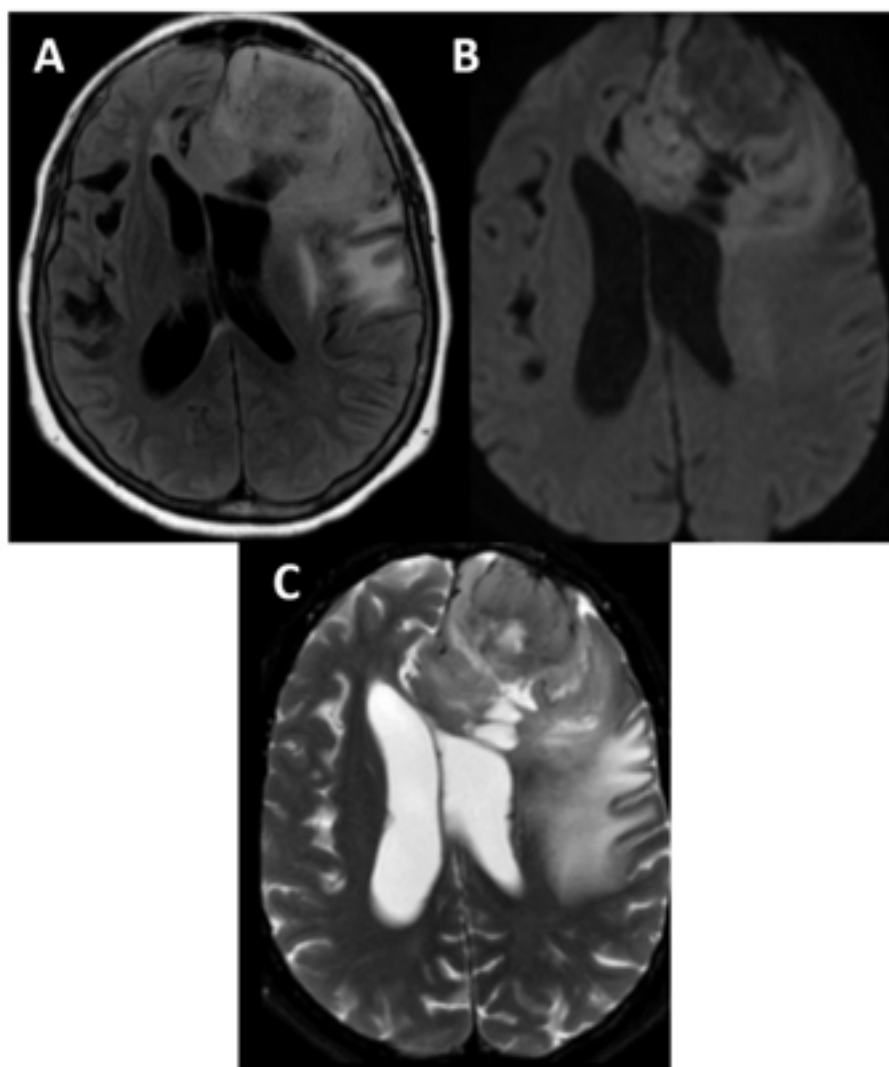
Skull MRI in axial sections, in FLAIR sequence (A), showing frontal infiltrative lesion on the left side with invasion of the corpus callosum and contralateral parenchyma; B100 diffusion (B), showing restricted diffusion in the infiltrative lesion; and T2 (C), showing dilation of the lateral ventricles and perilesional vasogenic edema.
